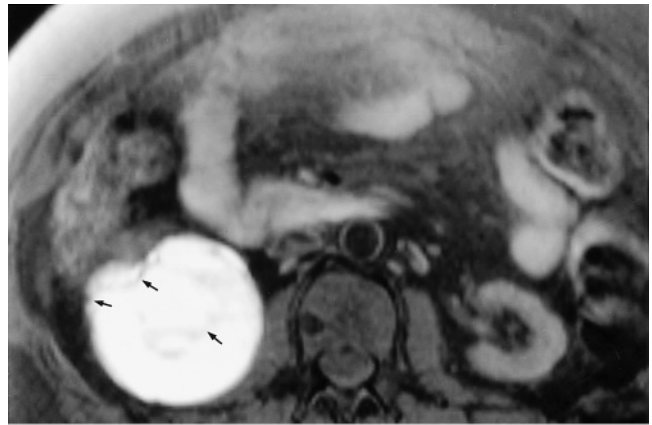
Hemorrhagic renal cancer in chronic renal failure. T1-weighted precontrast SGE (*a*), precontrast fat-suppressed SE (*b*), and interstitial-phase fat-suppressed gadolinium-enhanced SE (*c*) images. A 5-cm renal cancer is present in the right kidney (arrow, *a*) that is heterogeneously high in signal intensity on precontrast T1-weighted images (*a*, *b*), consistent with hemorrhage, and shows heterogeneous high-signal-intensity stroma on the postgadolinium image (*c*). T1-weighted fat-suppressed SE image (*d*) at a level immediately inferior to the renal cancer shows a hemorrhagic renal cyst with a fluid level (arrow, *d*). T1-weighted pre-contrast fat-suppressed SGE (*e*) and 90-s postgadolinium SGE (*f*) images in a second patient demonstrate a 5-cm tumor that is heterogeneously high in signal intensity on the precontrast fat-suppressed image (arrow, *e*) and is heterogeneously diminished in signal intensity on the postgadolinium image (*f*).
